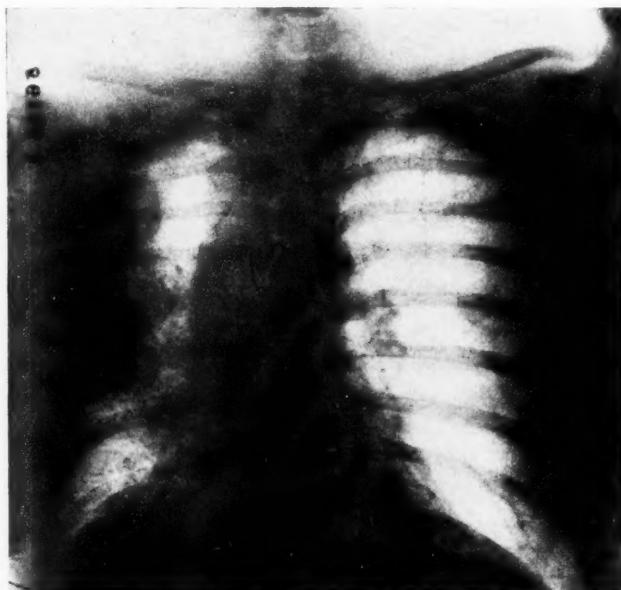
Case IV (Fbdy. No. 1085). Roentgenogram showing pulmonary abscess, fibrosis, displacement, and extensive pathologic changes due to the overlooked presence of a safety-pin in the lung for thirty-six years. Removed bloodlessly through the mouth, under local anesthesia, in nineteen minutes and seven seconds. (Film by Drs. Hicksy and Evans.)
